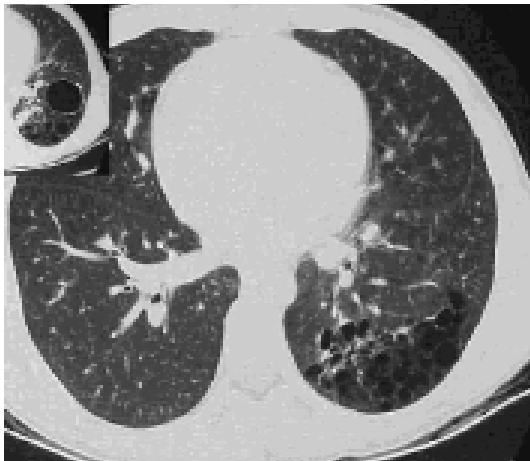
CT Scan of CCAM showing multilocular cysts with thin walls
